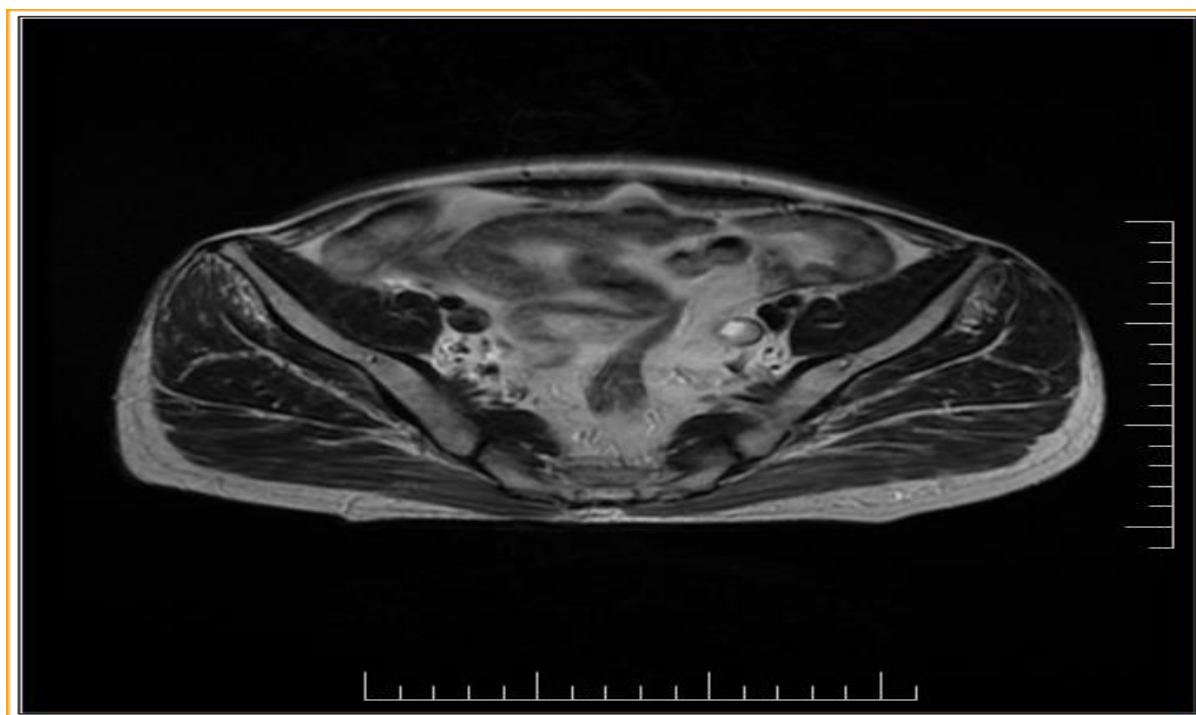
Axial image of MRI pelvis showing tumour
